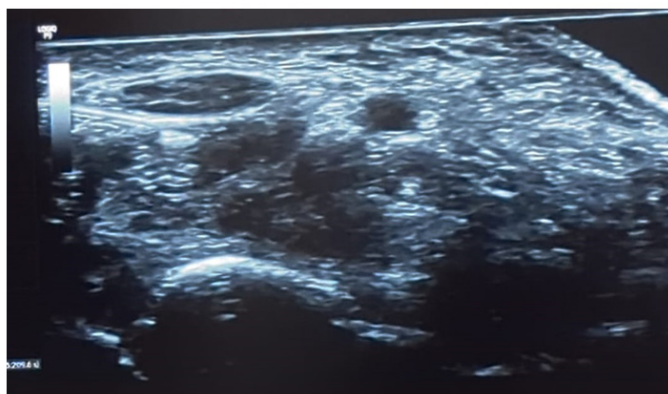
Ultrasound examination of the median nerve revealing an enlarged cross-sectional area of 13 mm², consistent with CTS diagnosis.
